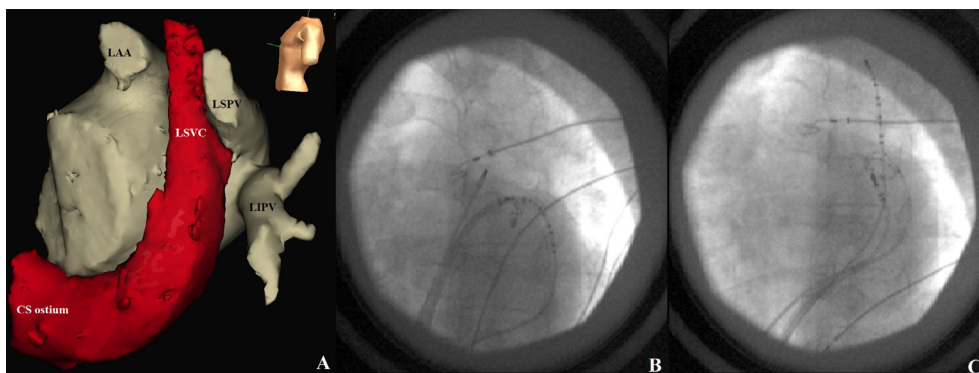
(A) Computed tomography image integrated to NavX map. Note the anatomical contiguity between LSV and LSPV. Fluoroscopic images in left anterior oblique projection demonstrating catheter positions. (B) Ablation and circular multielectrode catheters are in LSPV and CS catheter distal is in the LSV-CS junction. (C) Ablation and circular multielectrode catheters are in LSV and CS catheter is in the distal LSV.
